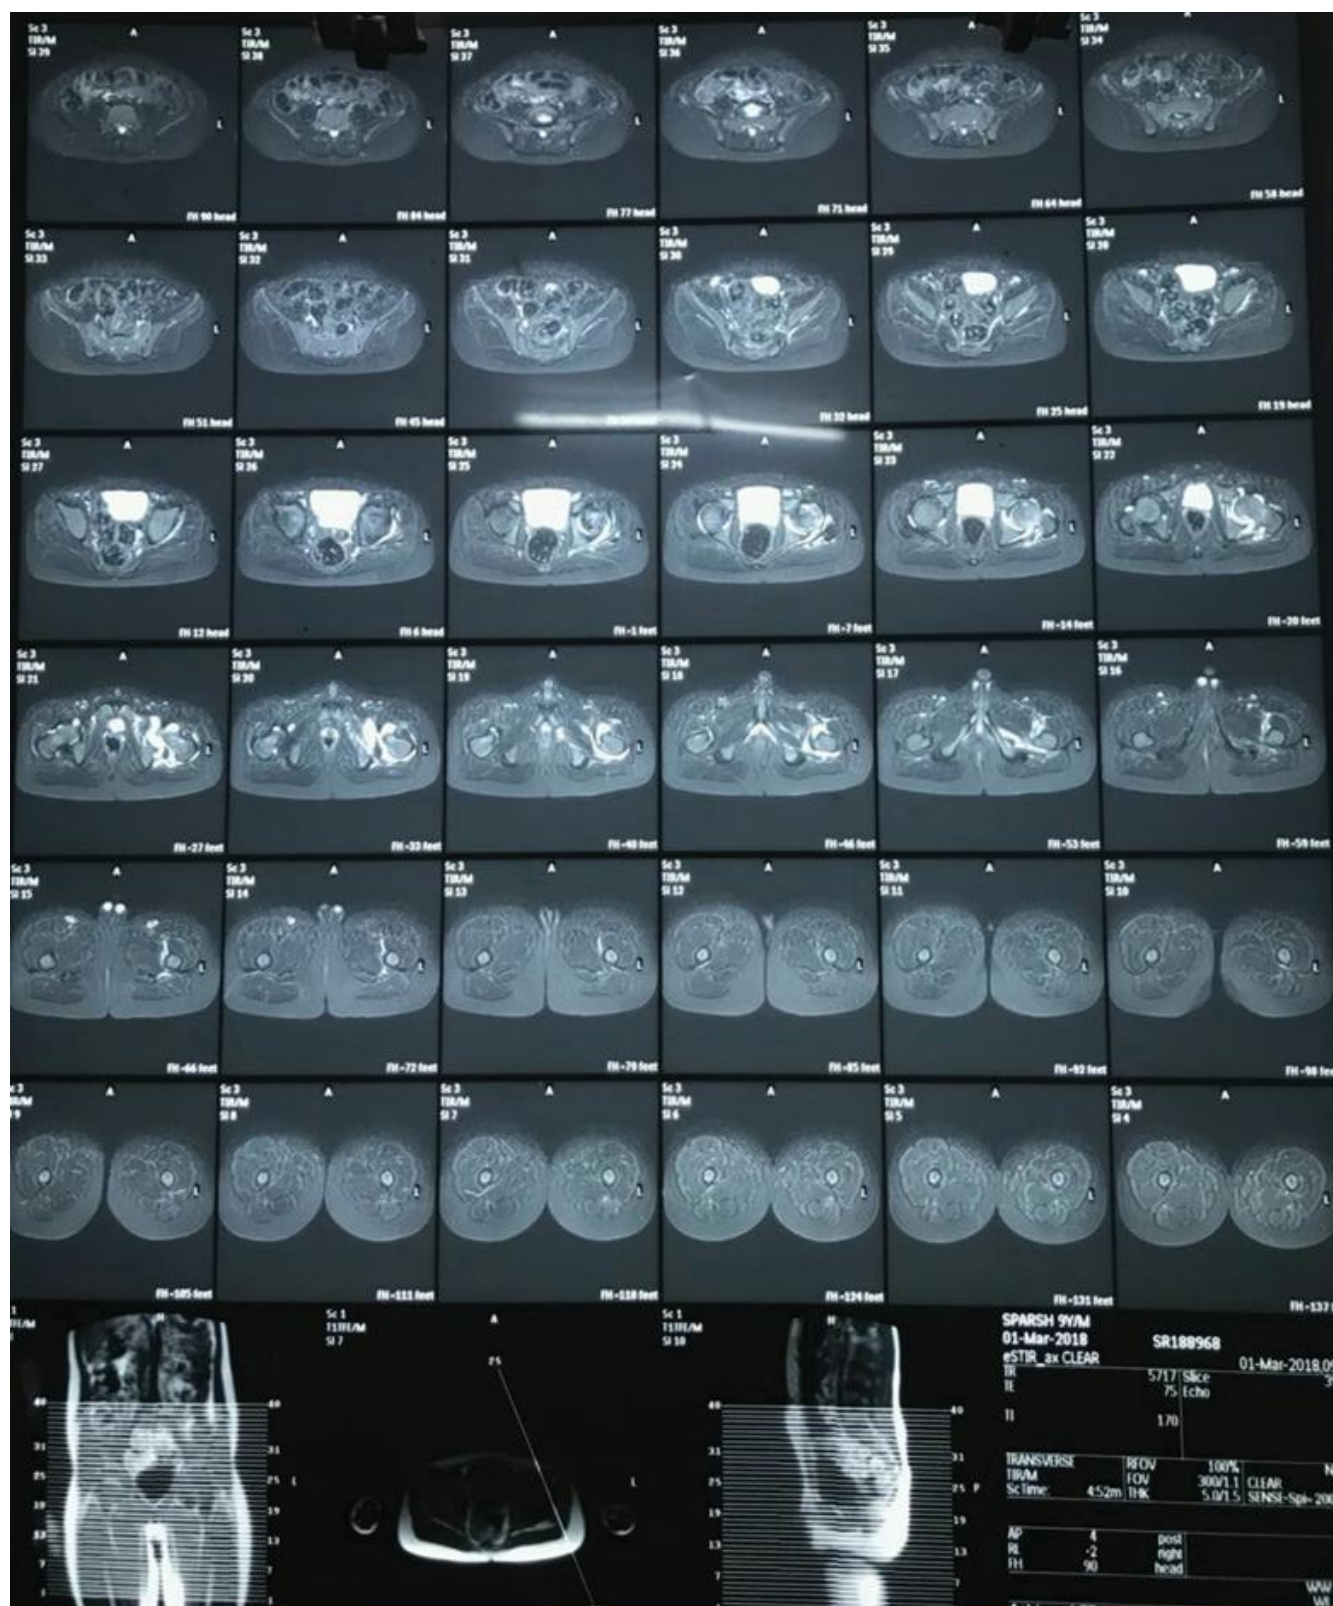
MRI of the Pelvis
